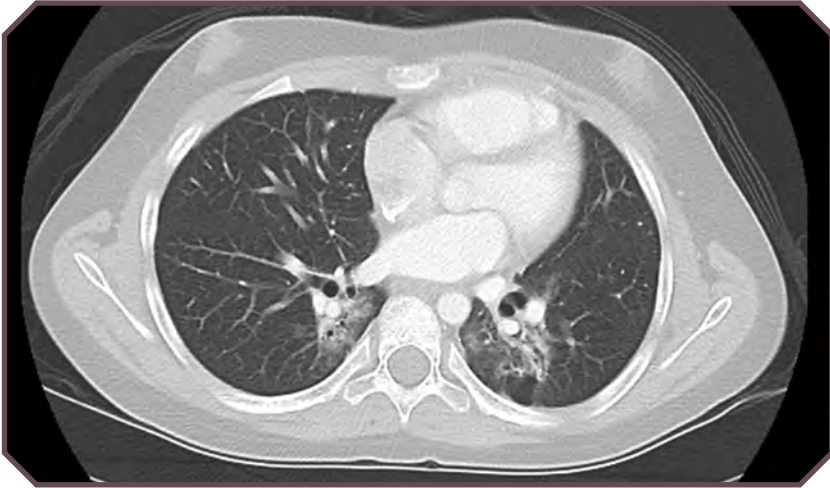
Combined pulmonary toxicity after combined chemotherapy with bleomycin, carmustine, cytarabine, doxorubicin, and radiation therapy. Axial computed tomographic image demonstrates coarse, bilateral, paramediastinal interstitial thickening, bronchiectasis, and scarring.
